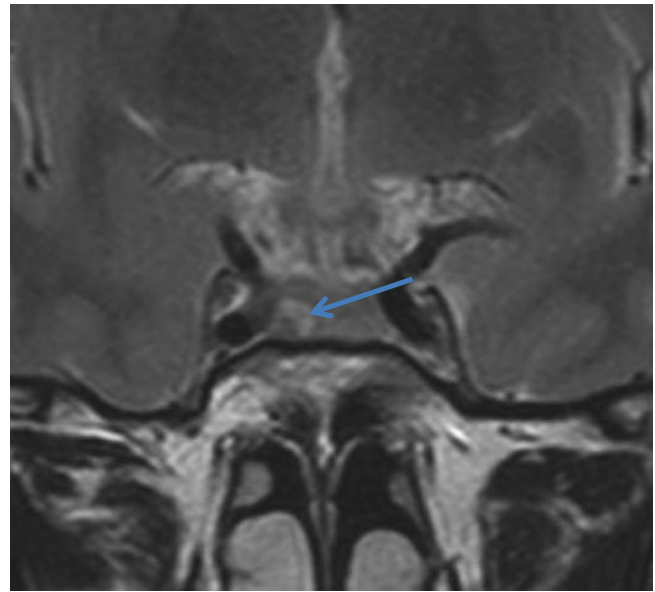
Microadenoma detected on non-enhanced images. (a) Coronal T2-weighted image showing a hyperintense microadenoma (arrow) at the right portion of the sella turcica.
